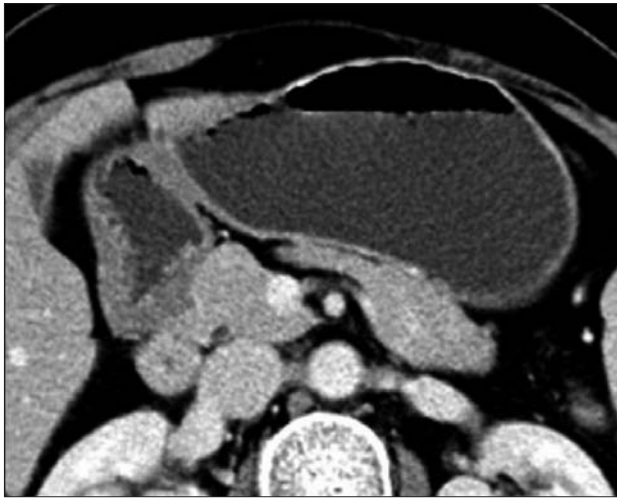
Contrast enhanced abdominal CT image of a 41-year-old woman with breast cancer demonstrates marked circumferential wall thickening of grade 1 distended antrum without gastric body wall thickening. Her stool antigen test was negative.
